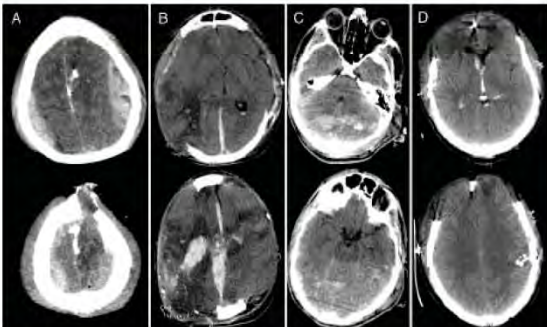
Computed tomography scans showing injury focus above the ventricles (A), at the ventricles (B), below the ventricles (C), and bifrontal (D).
